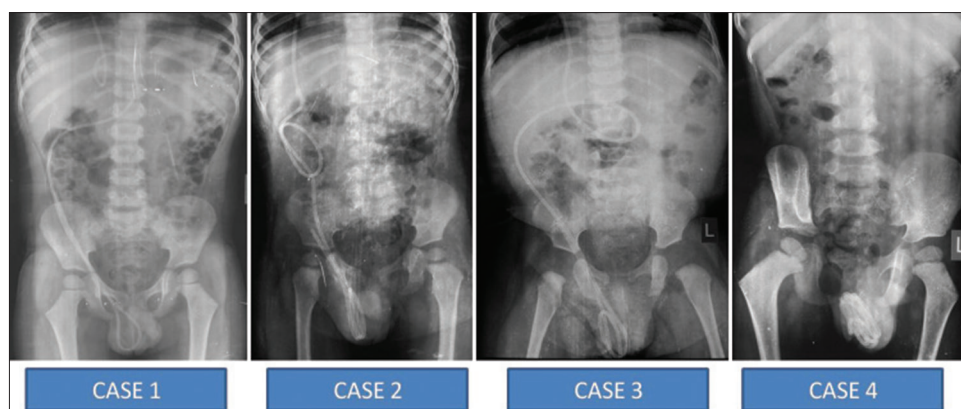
Abdominal X-rays showing migration of the shunt catheter
